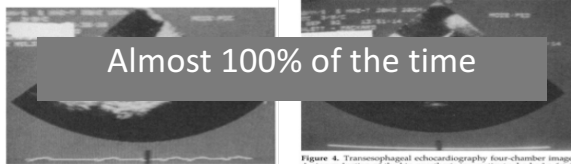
Transesophageal echocardiography four-chamber image during reduction of the hip prosthesis. 1 = right atrium; 2 = right ventricle; 3 = left ventricle.
